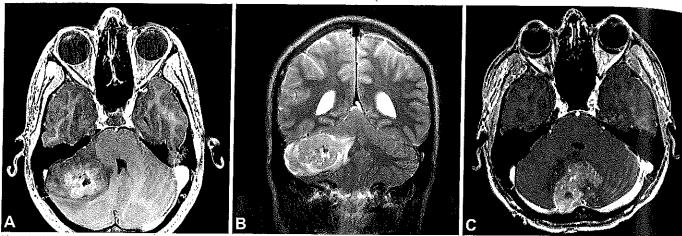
Desmoplastic/nodular medulioblastoma. A T1-weighted, (B) T2-weighted contrast-enhanced MRI of tumours in the cerebellar hemisphere. C T1-weighted, contrast-enhanced MRI of a tumour in the vermis.
